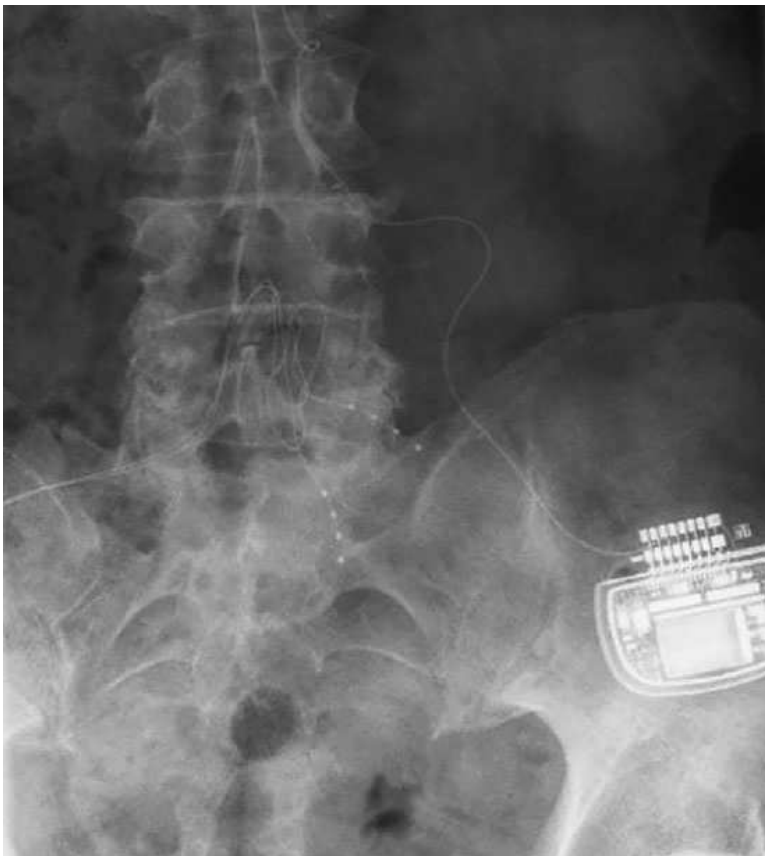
Postsurgical X-ray in patient no. 1 showing the strain relief loops, the extend of cranial epidural dissection performed (approximately one level) can be seen from the extend of loops reaching cranially. Used with permission from John Wiley & Sons - Books (Guilherme S. Piedade et al., 2019).
